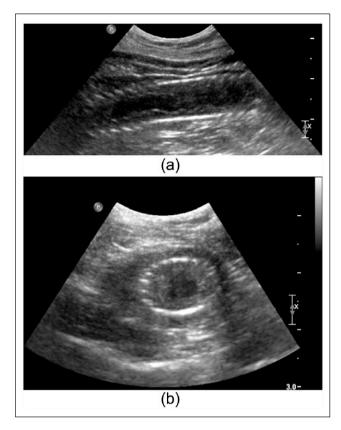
(a) Sagittal ultrasonographic image of the bladder neck and proximal urethra 8 days after placement of a metallic intravesical stent. Irregular soft tissue is seen encircling the stent and protruding slightly into its lumen. (b) Transverse ultrasonographic image of the bladder neck and proximal urethra 6 weeks after placement of a metallic intravesical stent. Irregular soft tissue is still seen encircling the stent and protruding slightly into its lumen
